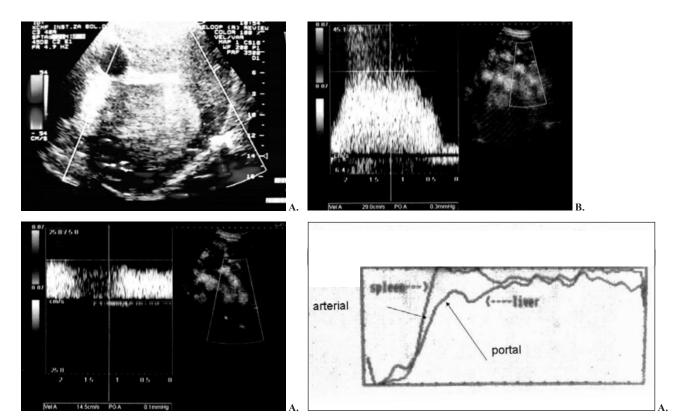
A: Color Doppler ultrasonography: colon carcinoma, with vascularisation on the periphery. B: Pulse flow velocity 29cm/s is registered on the periphery. C: Continuous flow velocity 14.5cm/s is also registered on the periphery. D: Hepatic radionuclide angiography: highly decreased hepatic perfusion index (HPI=0.05), in a patient with metastases from colon carcinoma.
